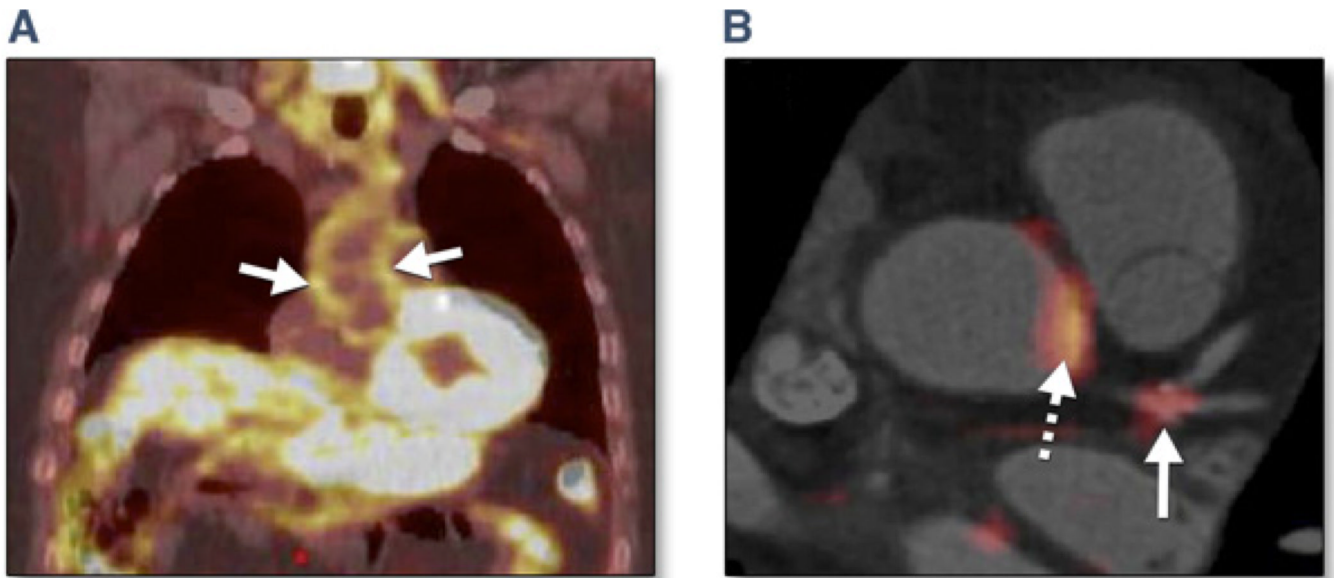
Imaging Arterial Inflammation Using FDG-PET
